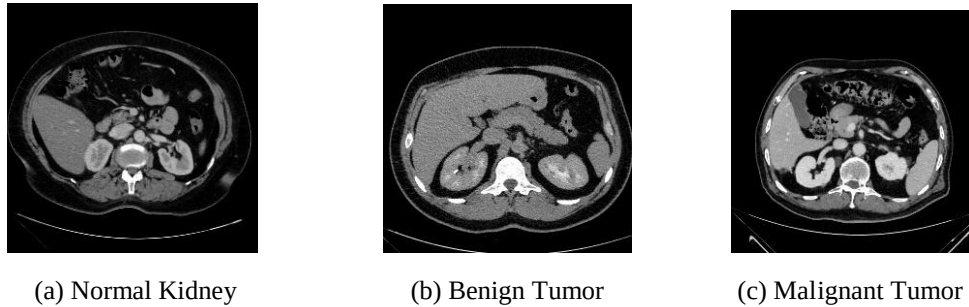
Representative axial CT images from the KAUH-Kidney dataset.
